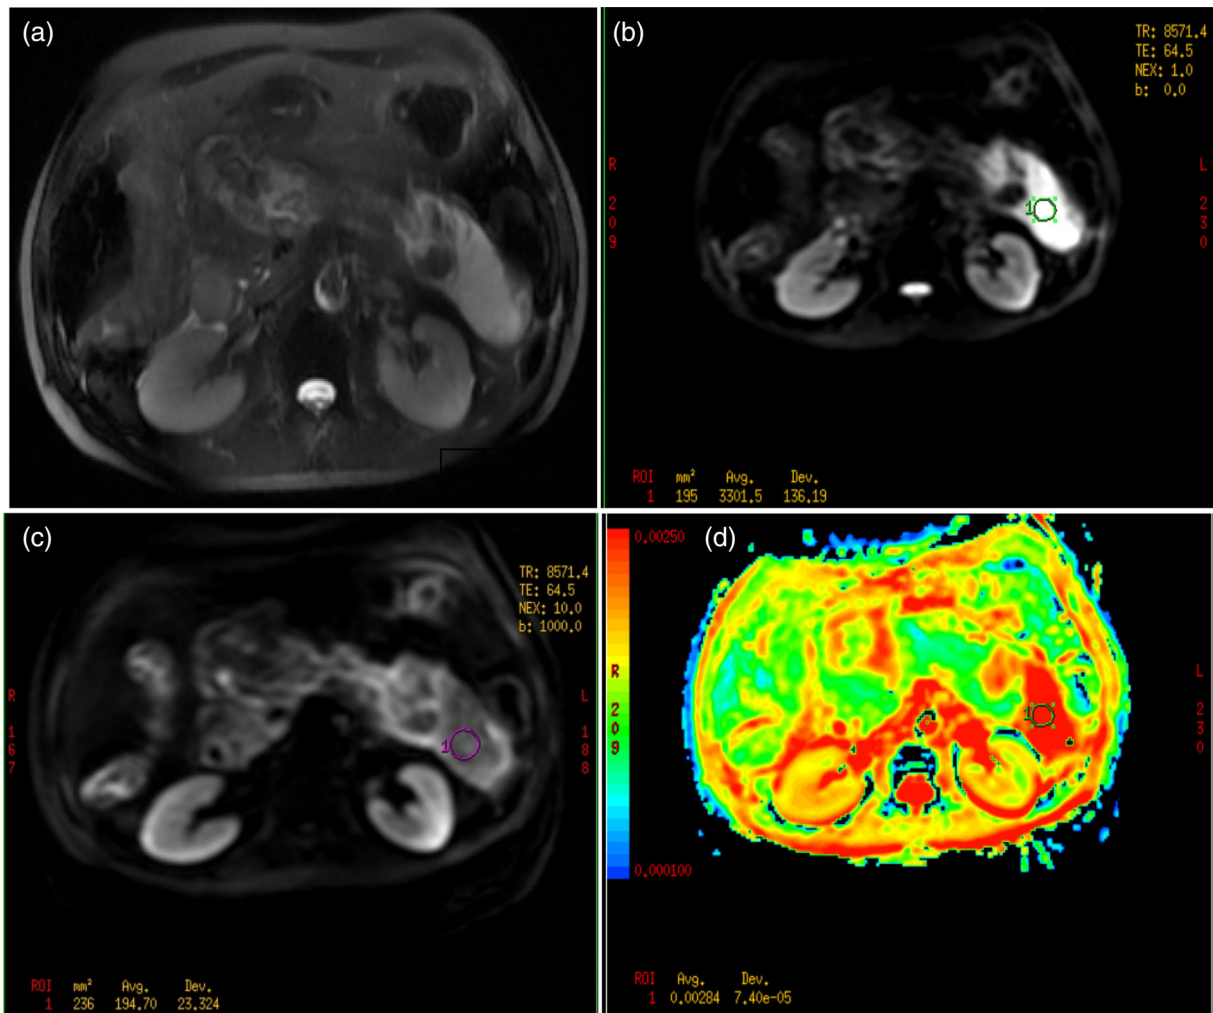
(a–d) A 54-year man with pancreatitis of biliary aetiology presented at 12th week of onset of the disease. (a) Axial T2-weighted single-shot fast spin-echo with fat saturation image showing the pancreatic necrotic collection in body and tail; (b) diffusion weighted image (b value = 0 mm²/s) with ADC mapping of region of interest (ROI). (c) Diffusion weighted image (b value = 1000 mm²/s) with ADC mapping of ROI. (d) ADC depicting value of ROI.
